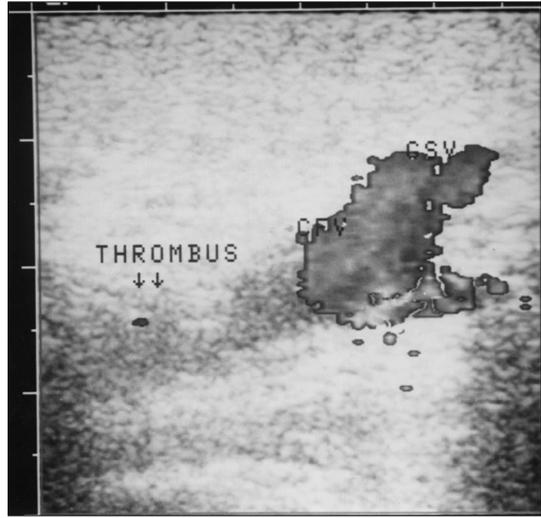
Color doppler study showed the echogenic material with discontinuous flow signal within a left femoral vein.
